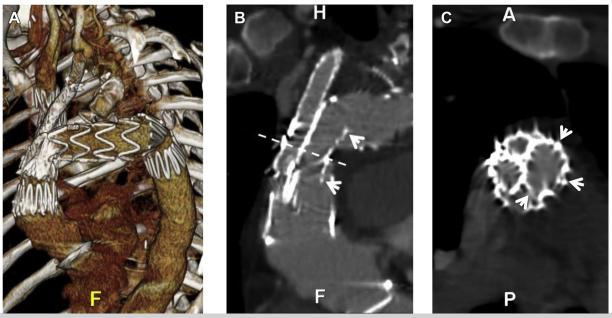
Computed tomography angiogram at 6 months of follow-up. A, Volume rendering demonstrating unchanged position of the endografts. B, Multiplanar reconstruction of the aortic arch. *Arrows* indicate the Palmaz XL stent (Palmaz Genesis; Cordis Corp) in unchanged expansion. C, Multiplanar perpendicular reconstruction at the level of the previous graft infolding (*dotted line*) showing well-expanded bridging covered stents to the innominate artery, left common carotid artery (LCCA), and well-expanded Palmaz XL stent (*arrows*).
